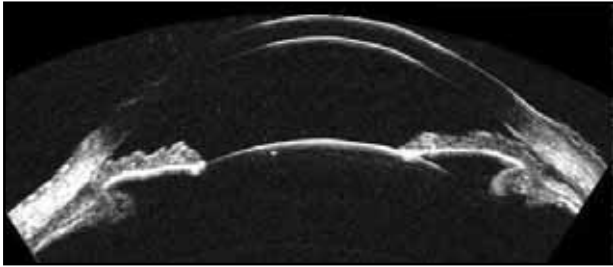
Full anterior segment horizontal VHF digital ultrasound B-scan encompassing a 15-mm wide sector. The anterior retina can be seen within this scan plane also. The angle-to-angle and sulcus-to-sulcus diameters are easily measured directly. Anterior chamber and posterior chamber volume and dimensions can be studied before insertion of phakic IOLs to predict the separation of such implants from the endothelium of the cornea, or the crystalline lens. Predictive effects on the angle due to posterior chamber phakic IOLs could also be made prospectively to improve patient safety.
